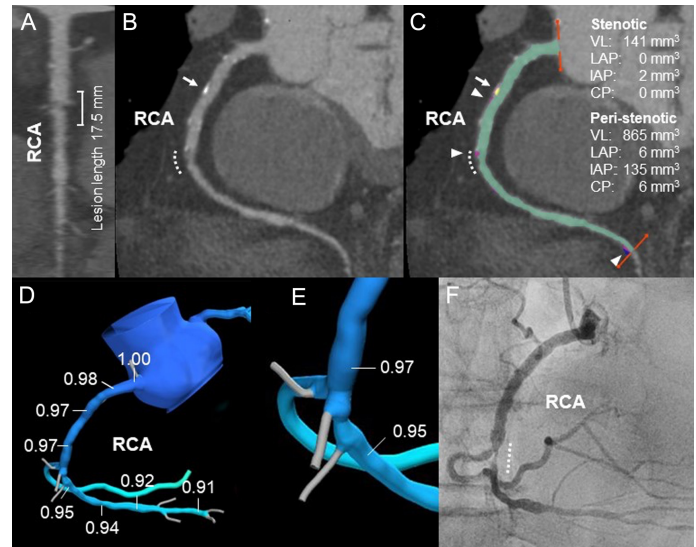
Case 1. Coronary computed tomography angiography (A–C): (A) Stretched multiplanar reformation. (B) Curved multiplanar reformation. (C) Vessel components. Green, VL; red, IAP; and yellow, CP. (D and E) Fractional flow reserve-derived computed tomography. $\Delta\text{FFR}_{\text{CT}}$ is the difference between the proximal and the distal segment of the stenotic lesion. (F) Invasive coronary angiography. The dotted line, arrowhead, and arrow indicate stenotic lesion, IAP, and CP, respectively. CP, calcified plaque; CCTA, coronary computed tomography angiography; FFR_{CT}, fractional flow reserve-derived computed tomography; IAP, intermediate-attenuation plaque; LAP, low-attenuation plaque; RCA, right coronary artery; VL, vessel lumen.
